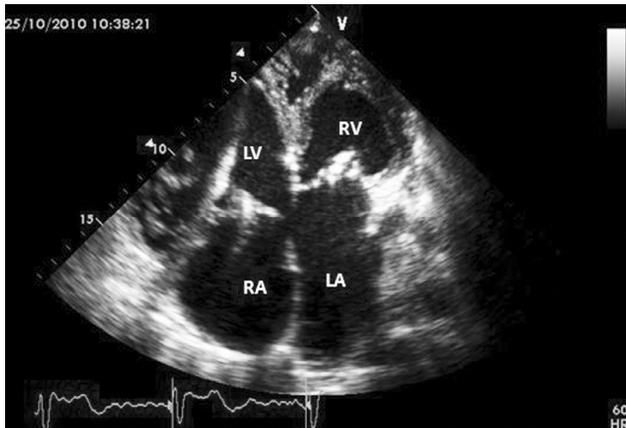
Apical four-chamber view of echocardiogram shows the anatomy in ccTGA: RA, right atrium; LV, left ventricle (subpulmonic); RV, right ventricle (systemic); LA, left atrium. Note the defibrillator lead inside LV.
